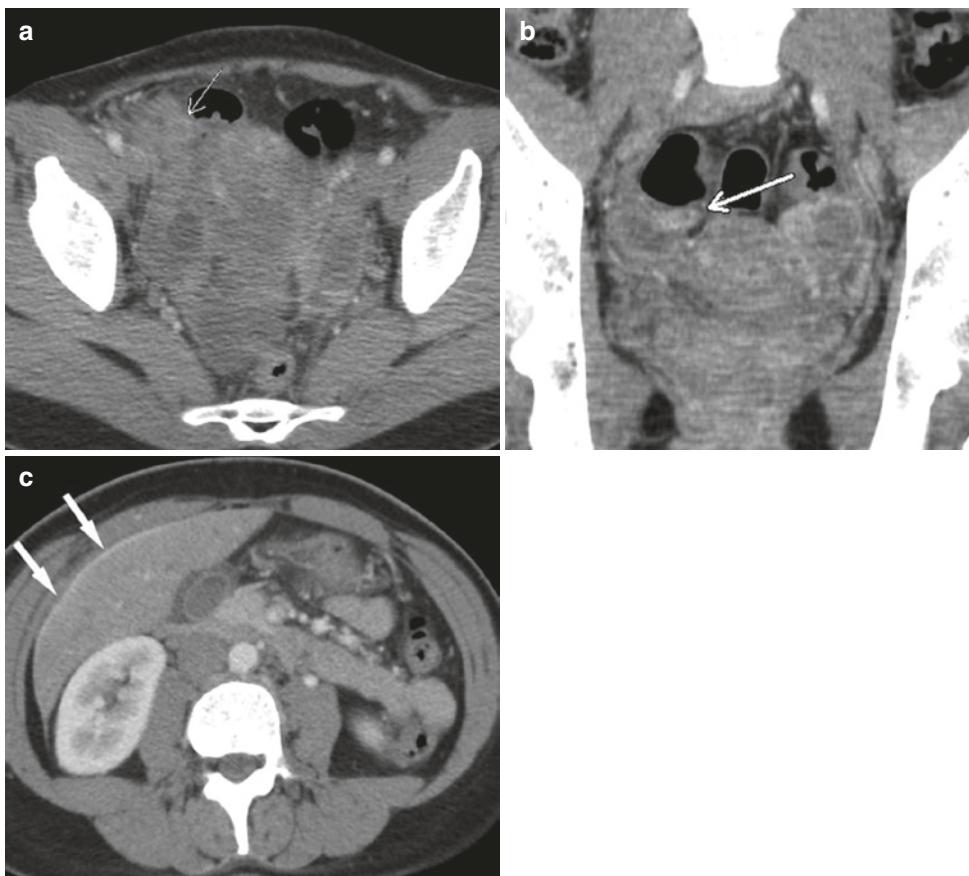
(a) CT of a 31-year-old woman who presented with peritoneal signs and fever with a rounded enhancing structure in the RLQ initially diagnosed as an inflamed appendix (arrow). (b) Coronal CT image show a tubular enhancing structure (arrow) called the inflamed appendix.
